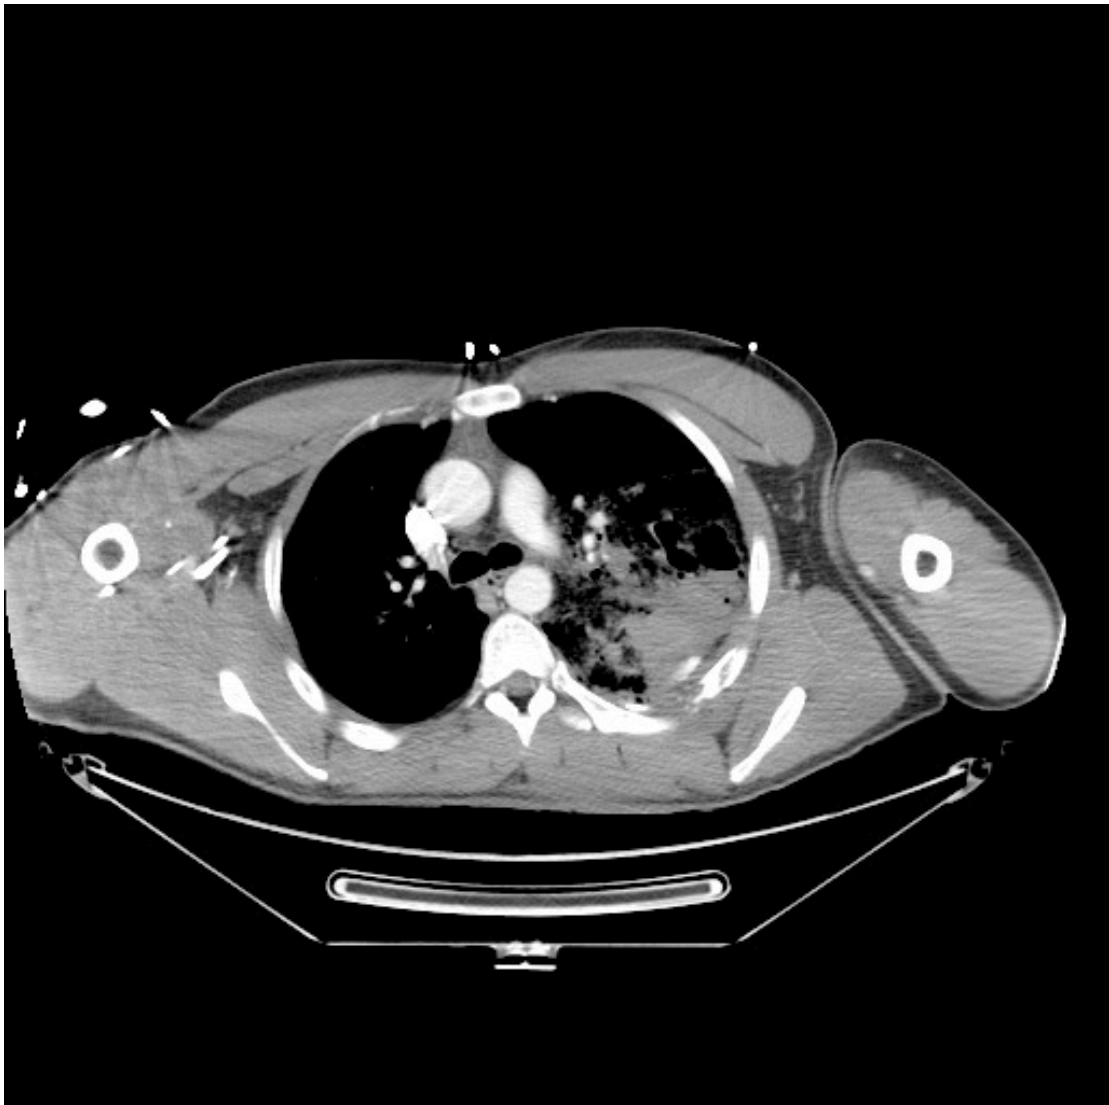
CT showing large lung laceration in the left upper lobe containing blood, with surrounding contusion and a tiny amount of pleural fluid but no pneumothorax. There is also a fracture to the left scapula, and fractures to the left 4th, 5th and 6th ribs.
